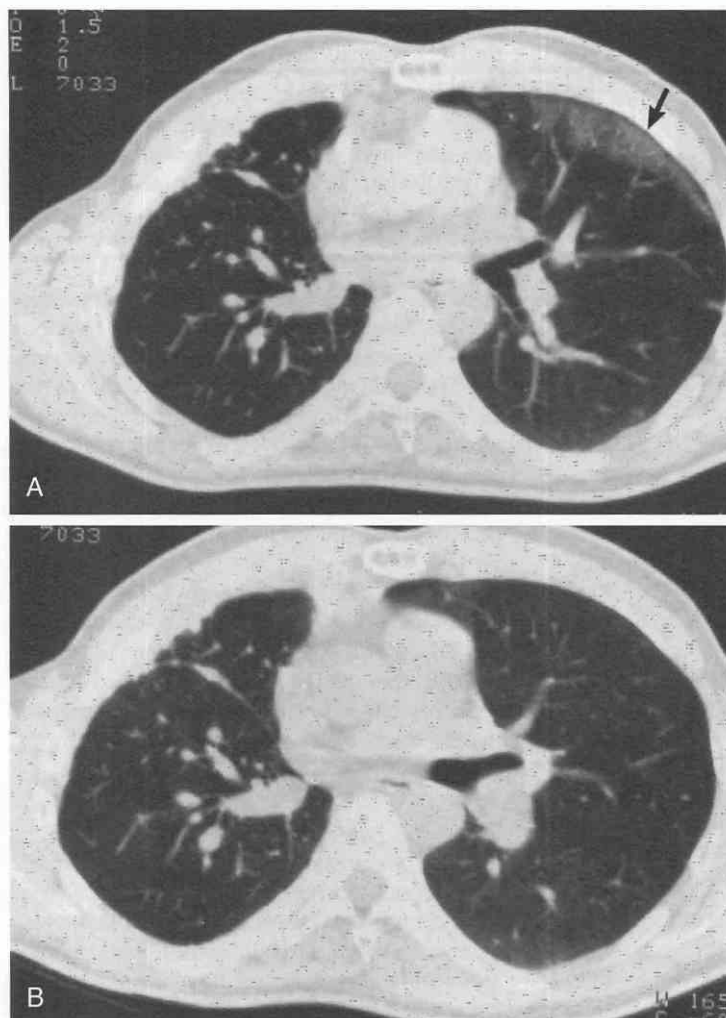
CT detection of drug-induced lung toxicity. Patient with recurrent lung cancer receiving ipomeanol, an investigational chemotherapeutic agent known to cause potential lung toxicity. *A*, CT shows development of a band of increased attenuation in the subpleural region, not detected on plain films (arrow). *B*, After discontinuation of the drug, the abnormality resolved.
